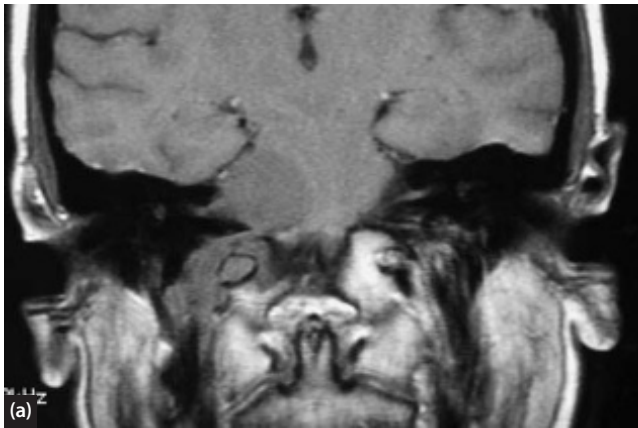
Chondrosarcoma of the right petrous apex that has spread into the cerebellopontine angle. (a) T1-weighted image, (b) gadolinium-enhanced T1-weighted image and (c) bone-windowed CT image of a chondrosarcoma that had spread into the cerebellopontine angle. The T1-weighted image shows low signal from the tumour, which becomes high with gadolinium enhancement. The CT scan shows foci of speckled calcification within the tumour that is characteristic of chondrosarcoma.
